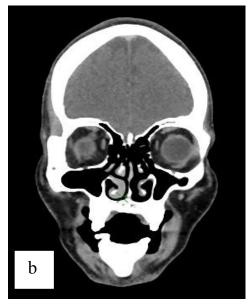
(a) Case 1 (Arterial phase CECT); (b) Case 1 (Puff cheek maneuver CT).
